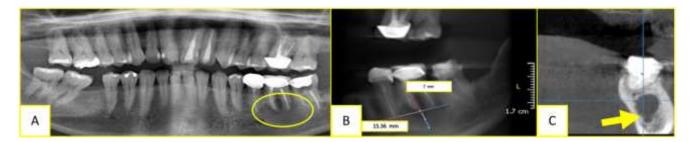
(A) Orthopantomography of tooth #36, periapical region with rarefaction involving both roots (circle); (B) CT, shows mesiodistal dimension 15.36 mm, coronoapical dimension of 7 mm of apical lesion; (C) CT scan shows contact of the lesion with the inferior alveolar nerve at the distal root (yellow arrow), decreased bone support.
